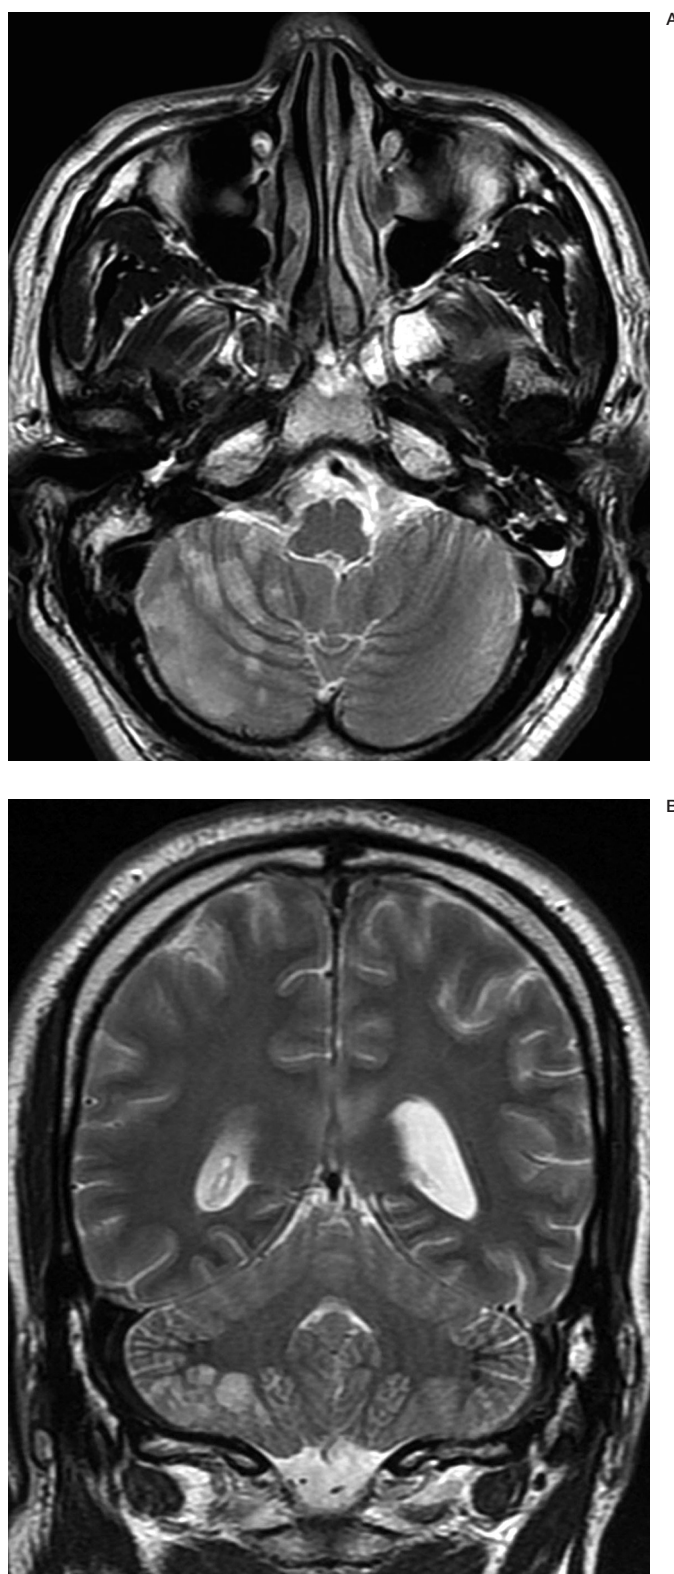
Magnetic resonance images (T2-weighted) showing ischemic lesions at the inferior aspect of the right cerebellar hemisphere on axial (A) and coronal (B) views.
